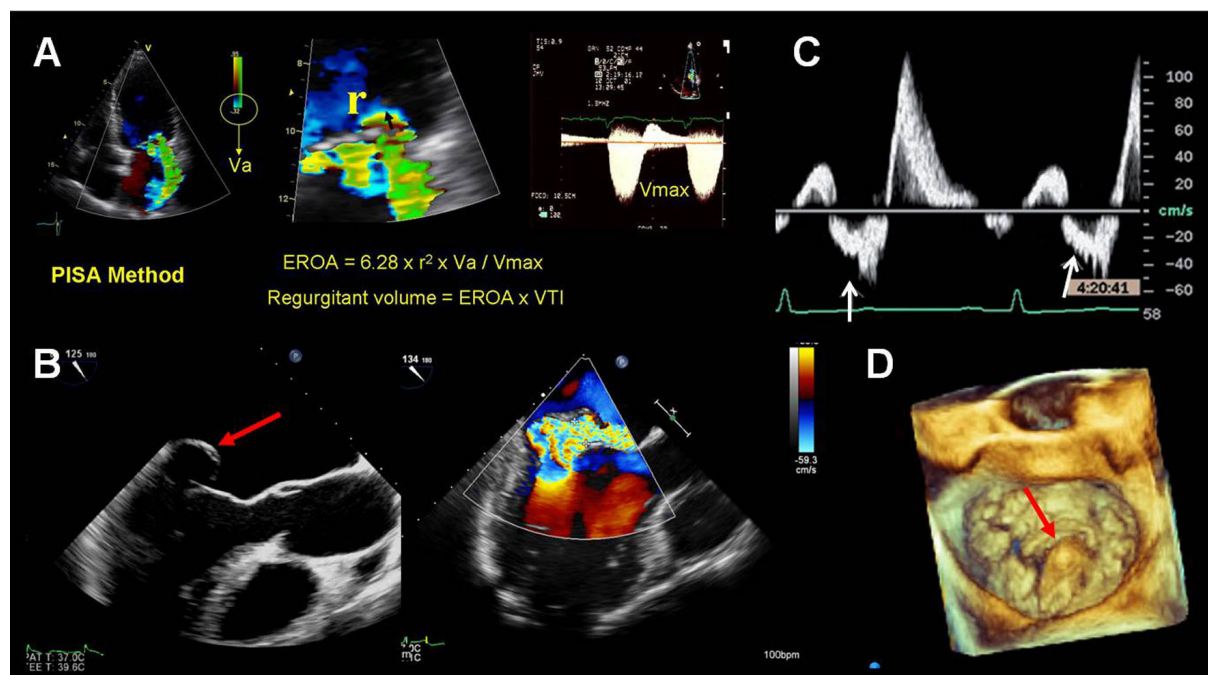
Assessment of the severity of mitral regurgitation (MR) and its etiology. Quantitative assessment of MR by the proximal isovelocity surface area (PISA) method to calculate the effective regurgitant orifice area (EROA) and regurgitant volume using transthoracic echocardiography (A). Transoesophageal echocardiography (TEE) permits detailed anatomy delineation of the mitral valve, showing severe MR (B) caused by a large mitral valve prolapse of the P2 scallop (red arrow). Colour Doppler study further confirms systolic flow reversal in the pulmonary veins (white arrows), indicative of severe MR (C). Real-time 3D TEE zoom view provides an en face visualisation of the diseased, mid mitral leaflet segment (red arrow in panel D), which is deemed suitable for MitraClip™ therapy.
